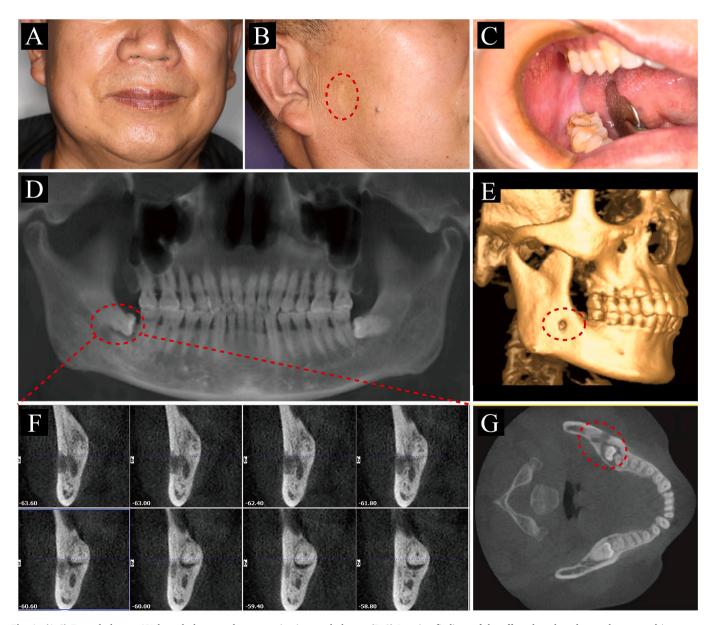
(A-C) Frontal photos, 45° lateral photos and preoperative intraoral photos. (D-G) Imaging findings of the affected teeth and secondary central jaw osteomyelitis in CBCT.
